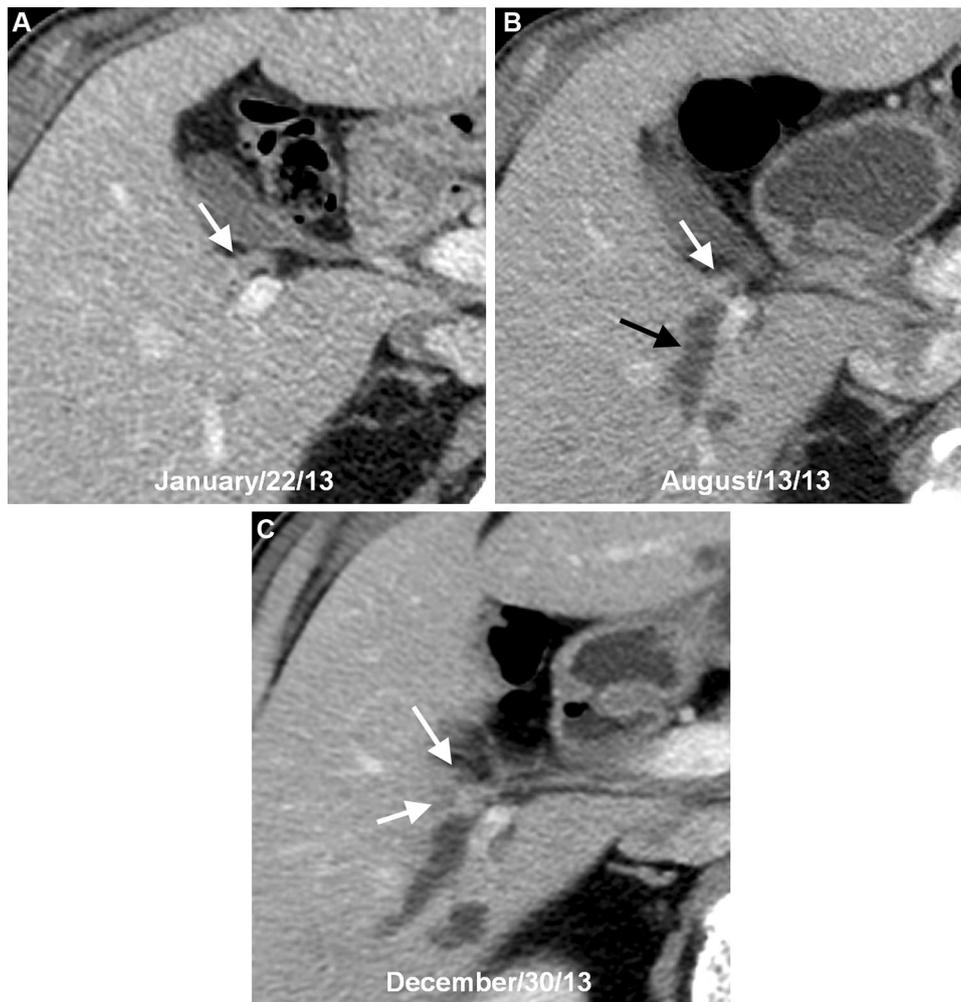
A 67 year-old man with double primary non-mass-forming cholangiocarcinoma and descending colon cancer. A Axial portal venous CT image obtained 51.5 months after operation for colon cancer shows duct wall thickening of right lobar duct and upstream IHF dilatation with abrupt tapering at transition
